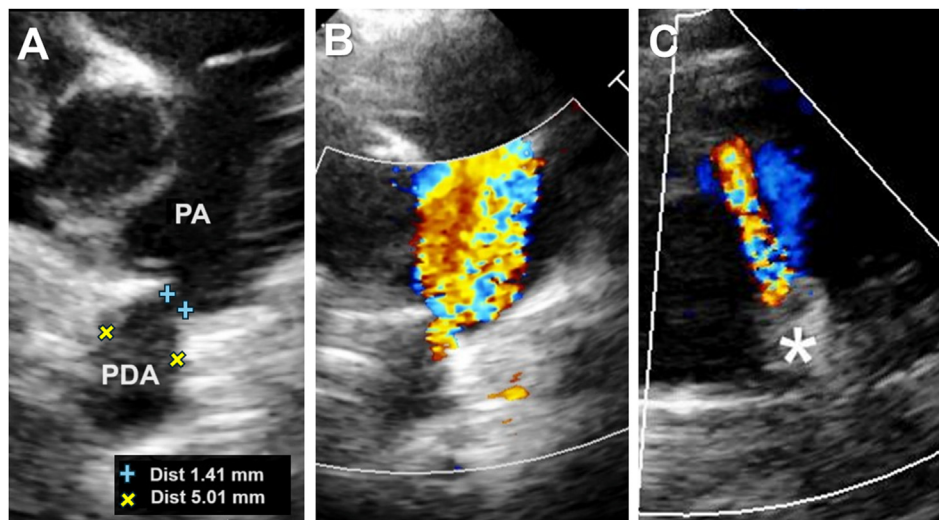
Echocardiographic images: (A) Right parasternal short-axis view at the level of the pulmonary artery: visualisation of the PDA with a minimal ductal diameter of 1.41 mm and an ampulla diameter of 5.01 mm. (B) Colour Doppler mapping (same view): continuous blood flow from the aorta to the pulmonary artery through the PDA. (C) Colour Doppler mapping (same view): minimal residual blood flow through the central part of the device (asterisk). PA: pulmonary artery; PDA: patent ductus arteriosus.
